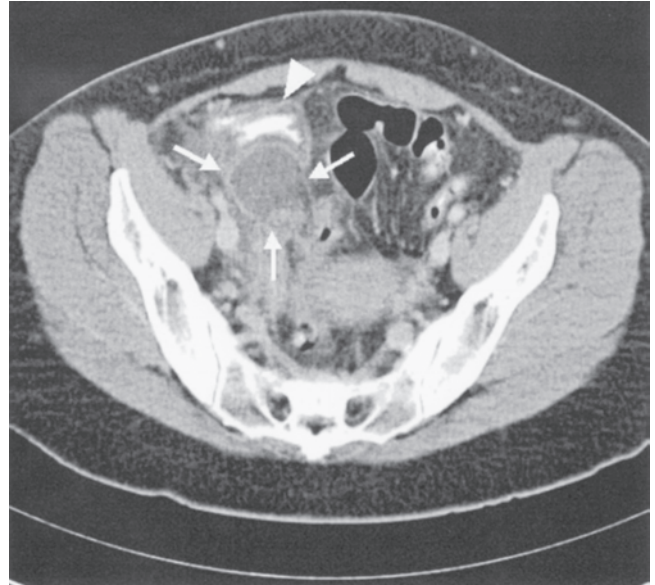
CT of perforated appendix. Note retrocecal abscess (*arrows*) with enhancing wall and periappendiceal fat stranding and adjacent cecal thickening (*arrowhead*). (Used, with permission, from M. Stephen Ledbetter, MD, MPH, Brigham and Women's Hospital, Boston, MA.)
